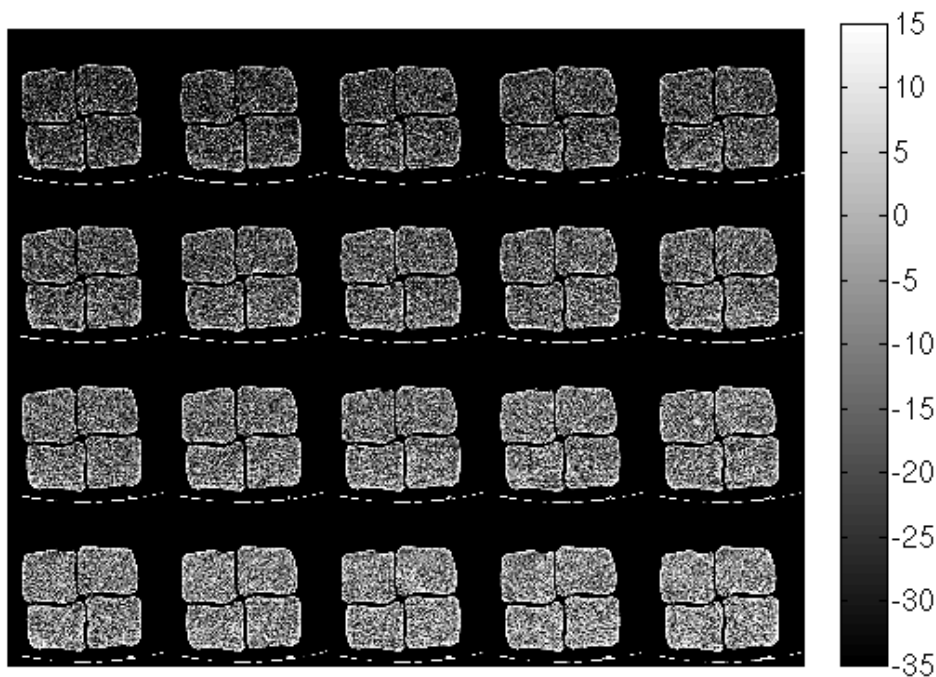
CT reconstruction of the four bottles as a function of time. The time increases (and thus the temperature decreases) from row to row starting from the top row, and from left to right within each row. Grayscale window: [-35, 15] HU.
